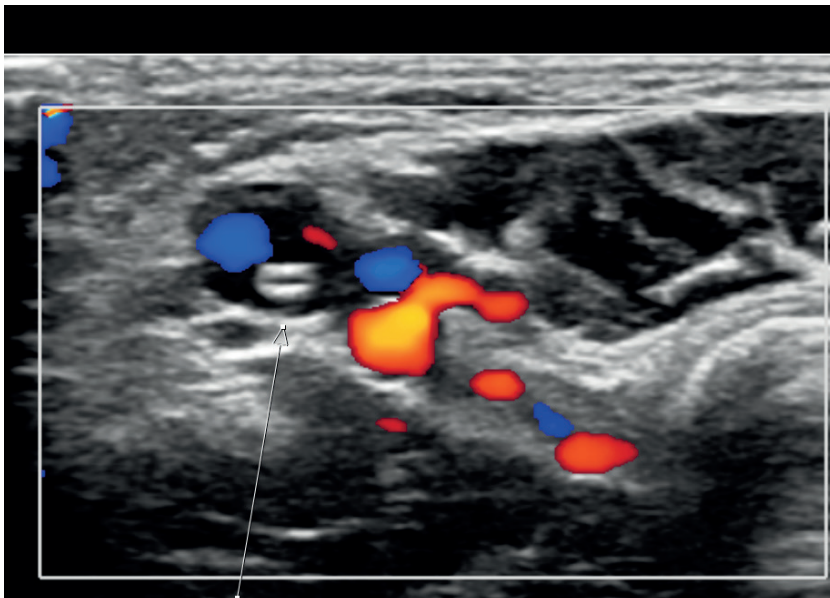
Ultrasonography of basilic vein with a midline catheter in place.
